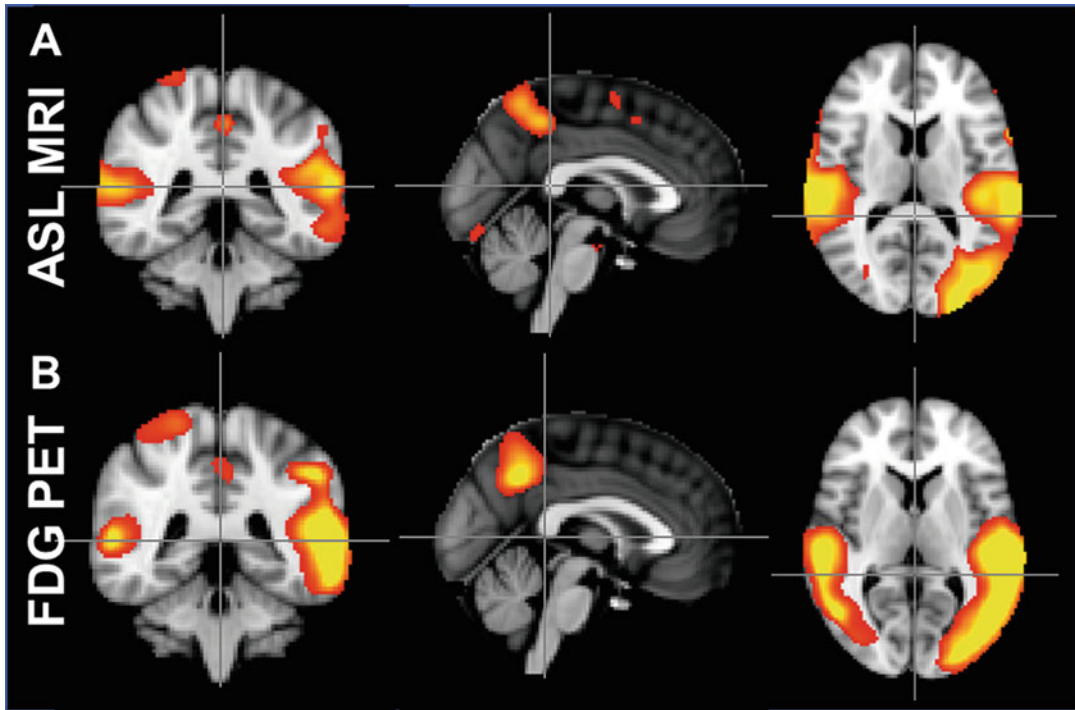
Hypoperfusion map on ASL MRI (a) closely resembles hypometabolism on FDG PET (b) in a patient with AD
